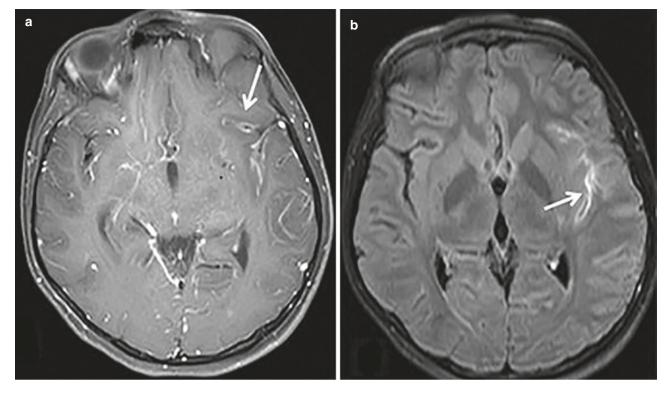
MRI scan of a patient suffering from meningitis as a complication of otits media. (a) Axial postcontrast T1 and (b) postcontrast FLAIR shows leptomeningeal enhancement in left sylvian fissure (arrow)
